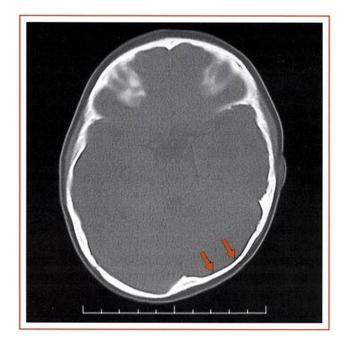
Bone windows of an axial CT scan. Arrows point to flattened left occipital. With occipital plagiocephaly the head assumes a trapezoid shape (in this case with the left side being in front of the right).
